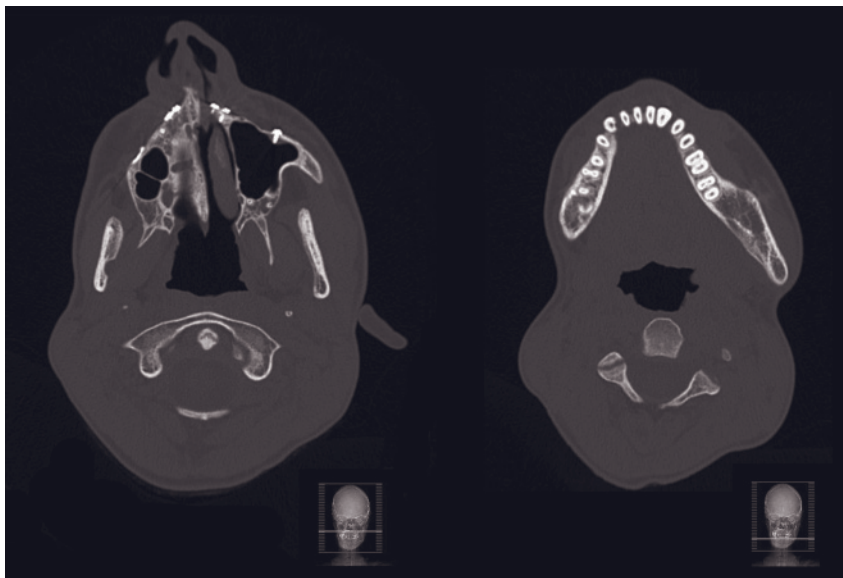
CT transverse sections of the maxilla and mandible in a patient with severe facial asymmetry.
